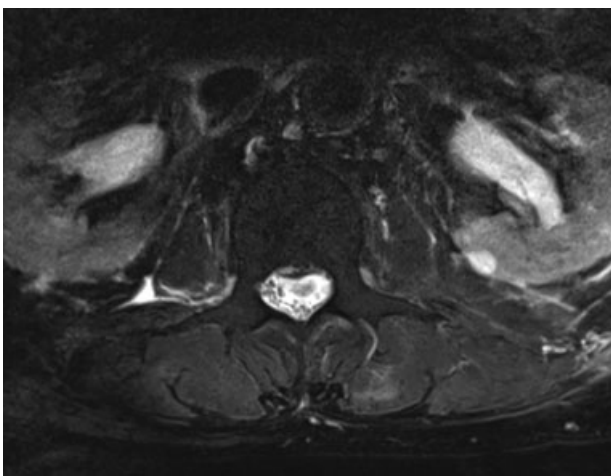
Axial T2-weighted lumbar magnetic resonance image at the L2-L3 level. The cauda equina is highly compressed with the fascicles being pushed laterally and posteriorly by the mass.
